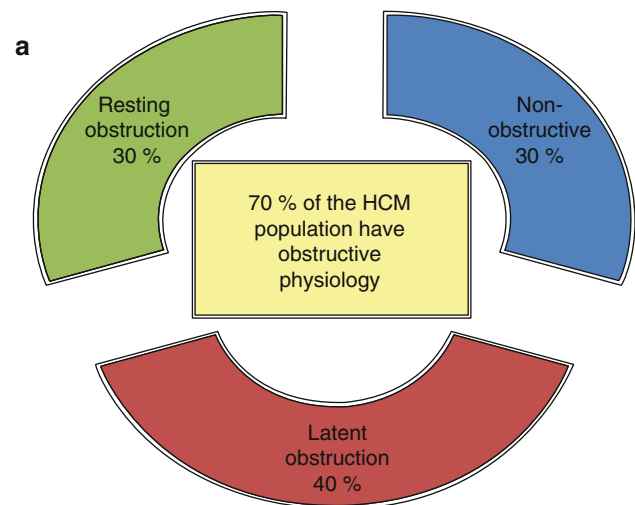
Obstructive HCM. As demonstrated in panel (a), patients with HCM can be grouped into three distinct hemodynamic categories based on the presence or absence of obstruction. Panel (b) (upper): Color Doppler and pulse wave Doppler demonstrating intracavitary obstruction. Panel (b) (lower): Color Doppler and continuous wave Doppler demonstrating left ventricular outflow tract obstruction and posteriorly directed mitral regurgitation
